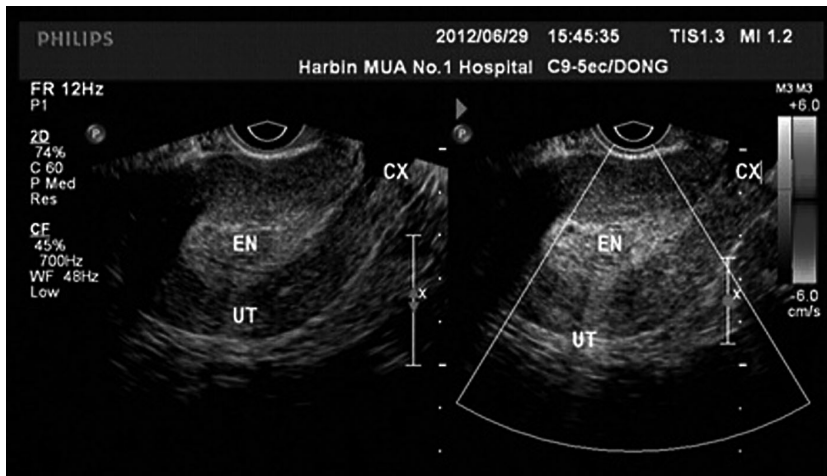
Endometrial hyperplasia by transvaginal ultrasound and color Doppler flow imaging.
